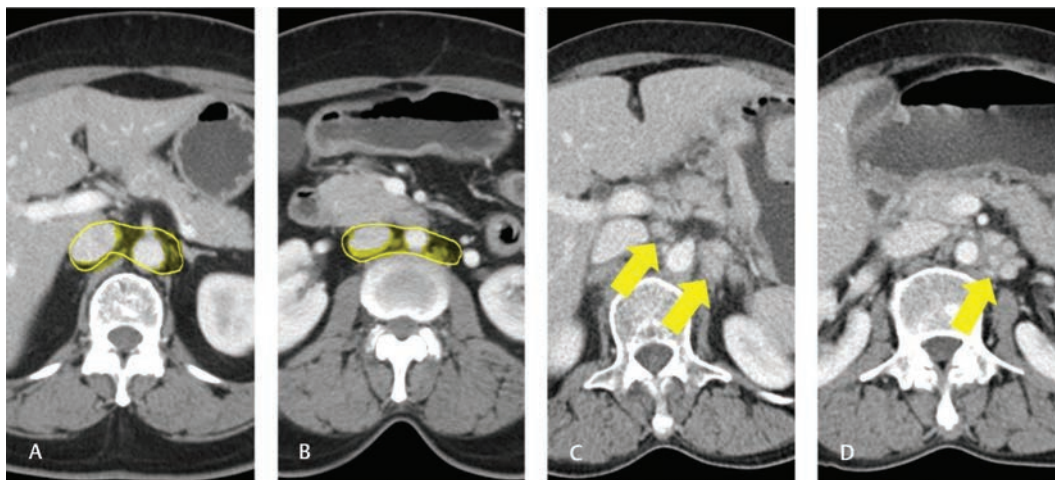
Station 16. Axial CT images (A) and (B) depicts station 16 location which encompass the retroperitoneal nodes in gastric cancer (yellow area in A and B). Axial CT image (C) shows enlarged retroperitoneal nodes and (D) shows small but multiple retroperitoneal nodes raising suspicion for metastatic involvement. CT, computed tomography.
